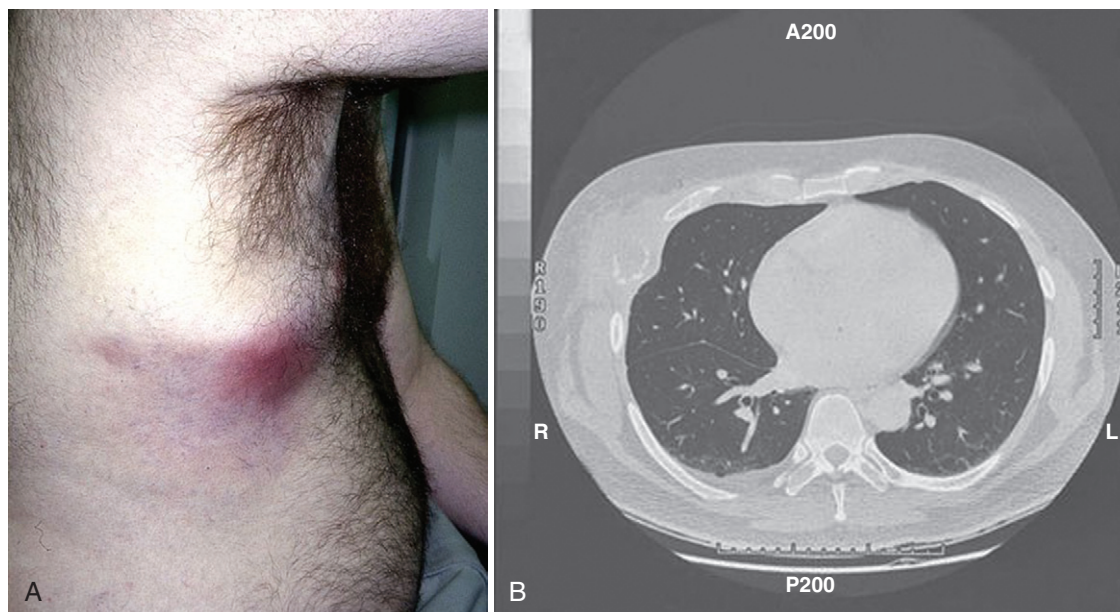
A, Blastomycosis osteomyelitis of a rib and chest wall. B, Computed tomography scan appearance. Primary infection in the blood may spread to the skeleton.
